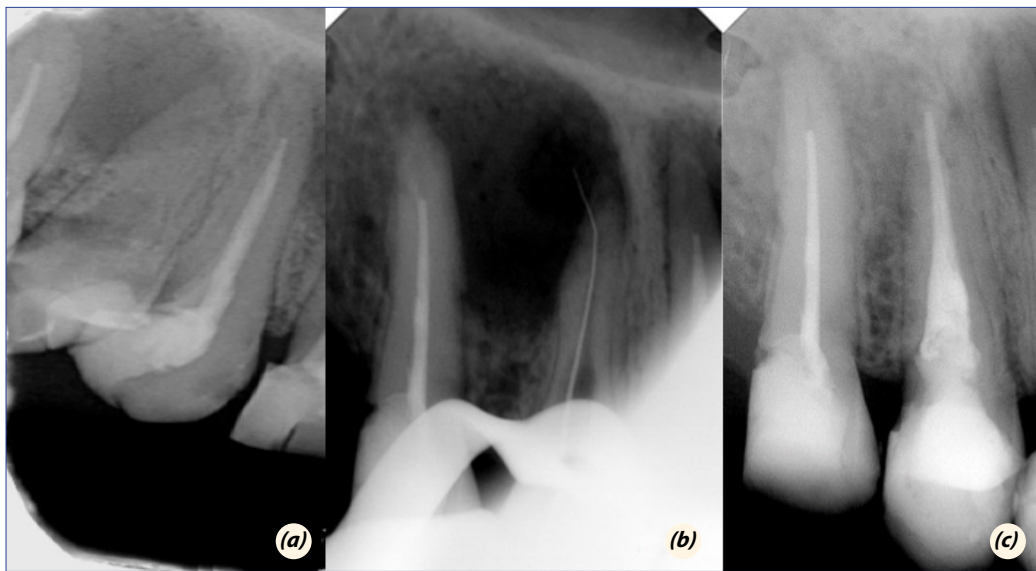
(a) Diagnostic periapical radiograph taken on radiographic examination– (b) Working length determination radiography - (c) 6 month follow-up radiograph.
